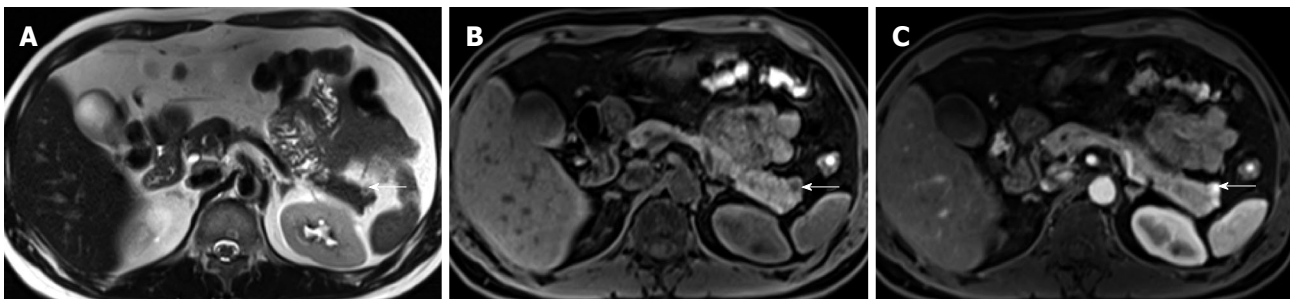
Axial magnetic resonance imaging images of a patient with Zollinger Ellison's syndrome. A: Axial non-contrast T2 weighted image of a patient with known Zollinger Ellison's syndrome secondary to a hyperfunctioning islet cell tumor (arrow) in the pancreatic tail. A T2 hyperintense nodule is present in the pancreatic tail. This corresponded to the site of increased tracer uptake on the octreotide scan (not shown). Note the relatively small size of the lesion, a finding that is typical for functioning islet cell tumors; B: Axial pre-contrast T1 weighted fat-suppressed image showing the lesion (arrow) to be hypointense. This contrasts well with the normal high signal of the pancreatic parenchyma; C: Axial post-contrast T1 weighted fat-suppressed image in the hepatic arterial phase showing avid enhancement within the lesion (arrow). This is the typical enhancement pattern of a neuroendocrine tumor.
